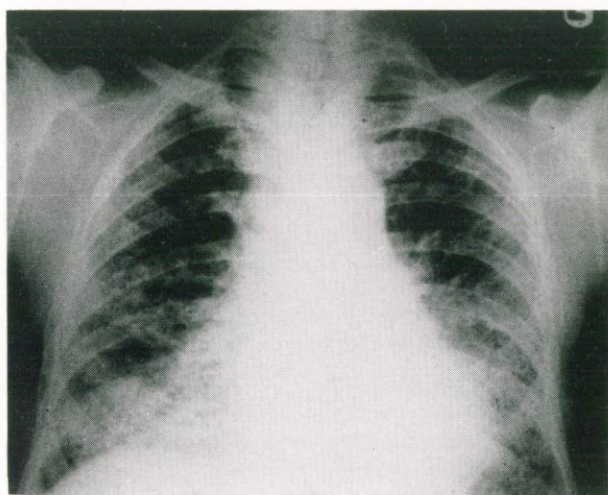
Chest x-ray in asbestosis: irregular opacities are present in both lower zones.
